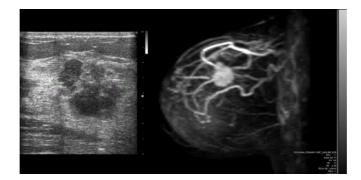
Imaging results obtained in a 40-year old woman included in the regular screening programme for mammography show a mass with irregular margins in the upper inner quadrant of the left breast (maximum diameter 25 mm; image not available because performed in another centre). The patient was then referred for further characterization. Left panel: US imaging confirms the inhomogeneous mass with irregular margins in the left breast. Right panel: MRI with gadolinium contrast shows that the mass has ductal-type contrast enhancement, suggesting breast cancer (confirmed by needle core biopsy as infiltrating ductal carcinoma).
